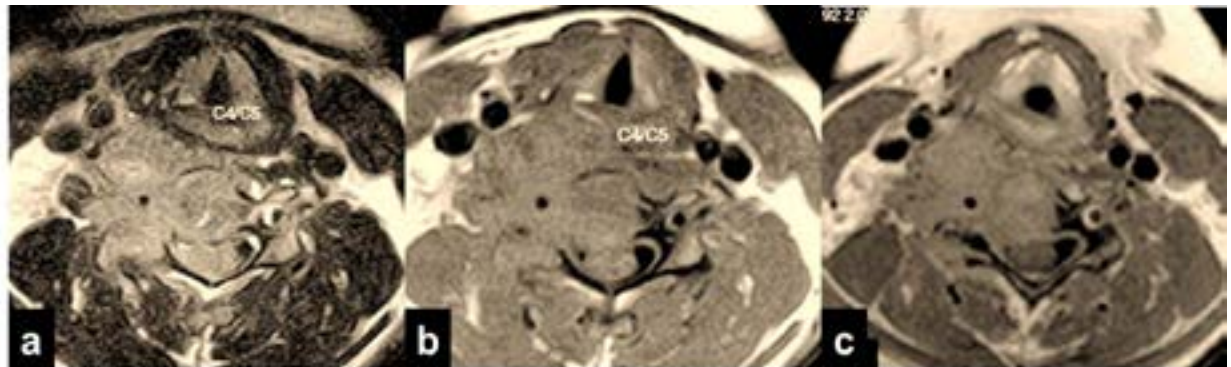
Axial MRI of Cervical spine - (a) T2, (b) T1, (c) Post IV Gad. A minimally enhancing soft tissue mass on the right side infiltrating the C5 vertebra and encasing the right neural foramen is shown. This mass extends into the spinal cavity obliterating the theca sac and compressing on the spinal cord.
